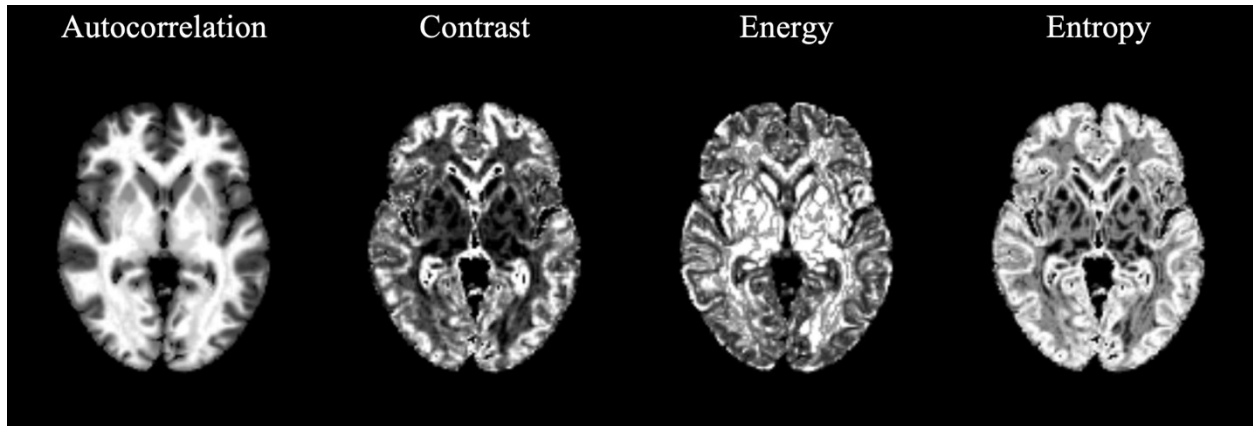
Three-dimensional maps of commonly used GLCM-based texture features extracted from a T1-weighted image of a healthy control.
